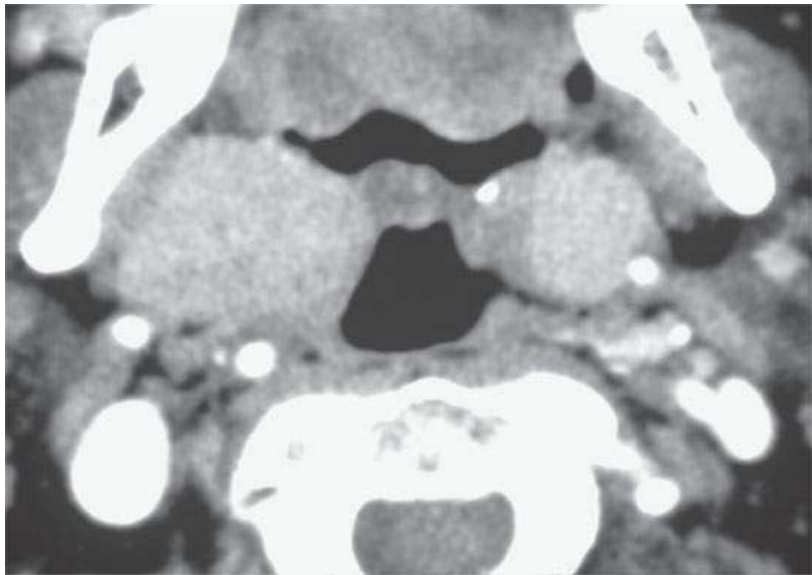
Contrast-enhanced computed tomography of a patient with multiple rhabdomyomas of the parapharyngeal space showing the tendency for unrestrained tumors to grow essentially spherically.
